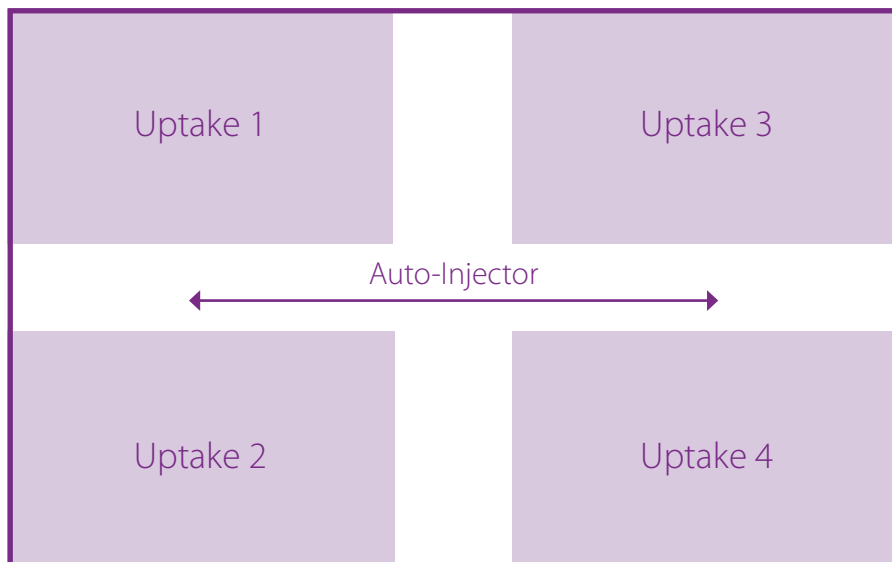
An example of the layout and functionality of the PET uptake rooms if an auto-dispenser and injector are to be used to administer $[^{18}\text{F}]\text{FDG}$
